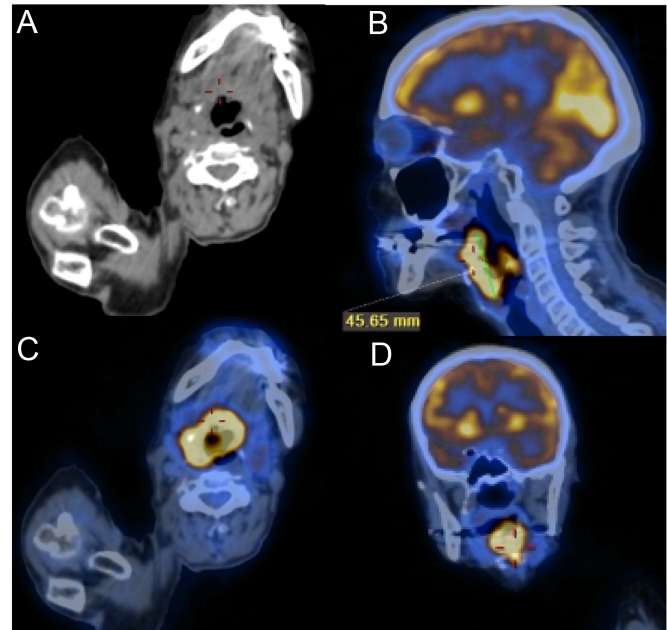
(A) Computed tomography scan of the neck reveals a tissue thickening at the right base of the tongue that involves the epiglottis caudally. (B-D) Positron emission tomography computed tomography shows increased metabolic activity on the right side of the base of the tongue (SUV 29) which extends to the epiglottis and right pyriform sinus, without secondary foci.
